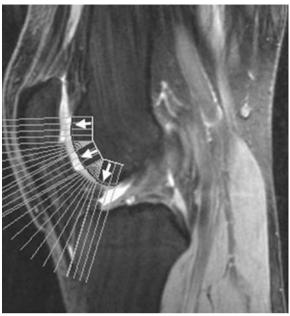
T2-weighted MR data of a human knee. Extraction of the bone surface by scanning form inside the bone.
